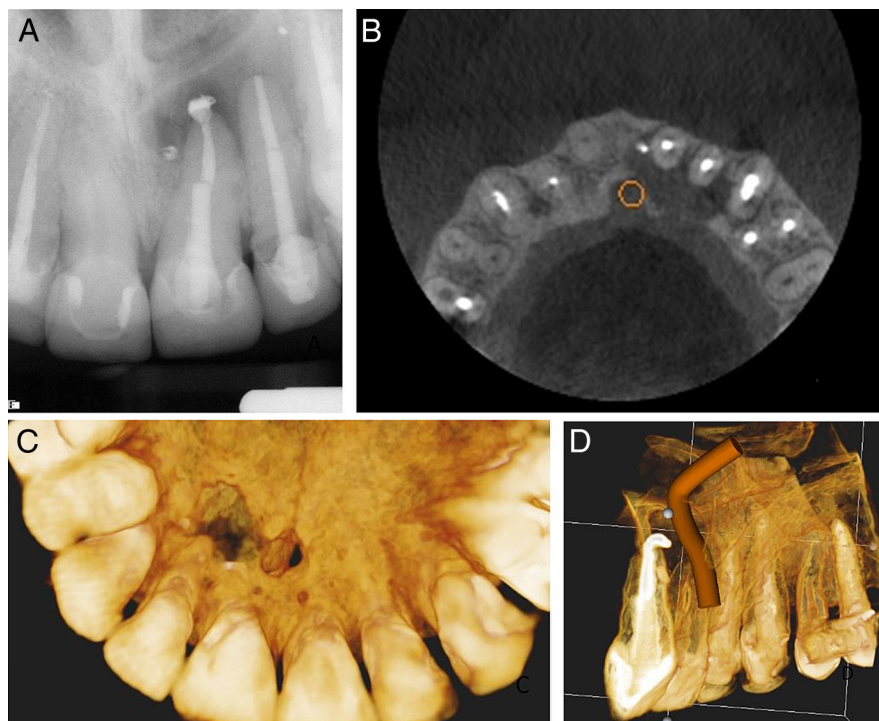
Case 4: (A) A periapical radiograph of the maxillary anterior region showing a periapical lesion associated with tooth #9. (B) An axial view showing the extent of the lesion, palatal plate perforation, and relationship of the nasopalatine neurovascular bundle to the periapical lesion. (C) A palatal view of the 3D reconstruction showing perforation of the palatal plate. (D) A 3D reconstruction showing the nasopalatine bundle.
